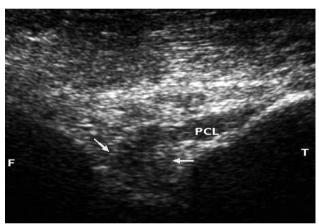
Ultrasound image showing contused thickened PCL at femoral attachment (arrows).
